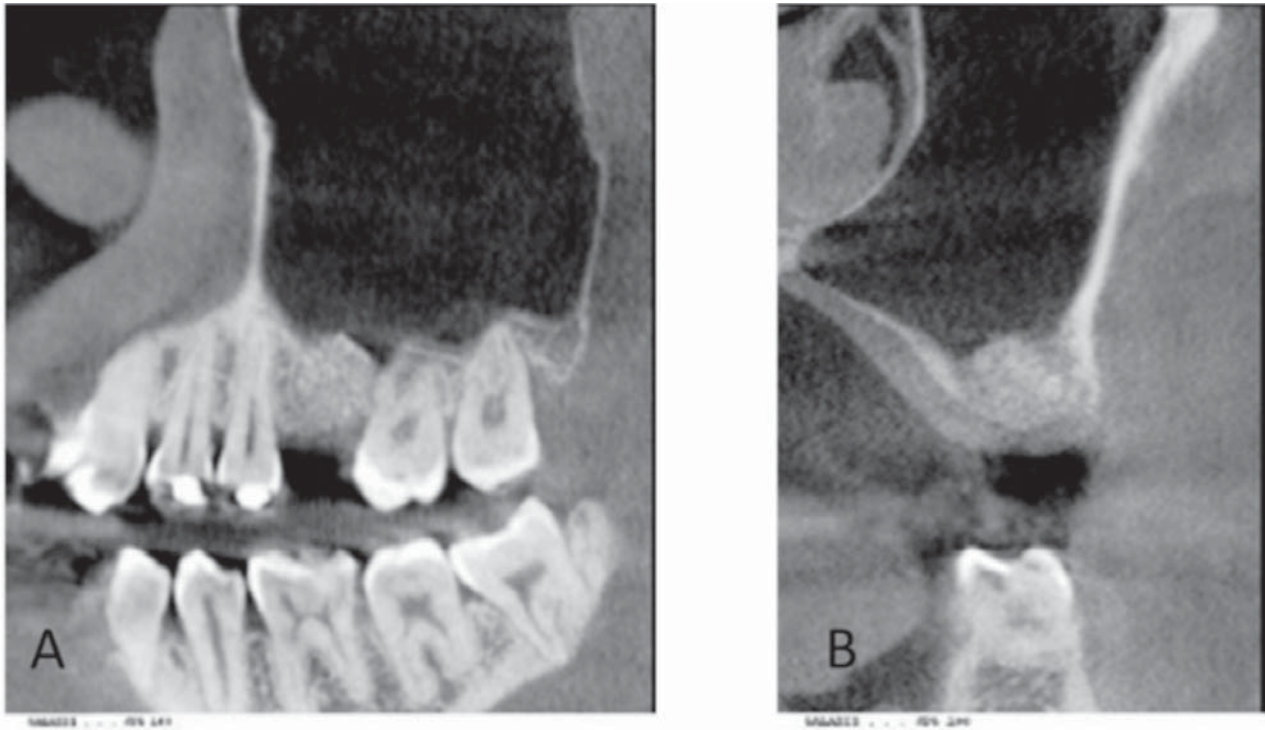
Cone beam computed tomography (CBCT). Six months after the sinus augmentation procedure. A: Frontal view; B: Sagittal view.
